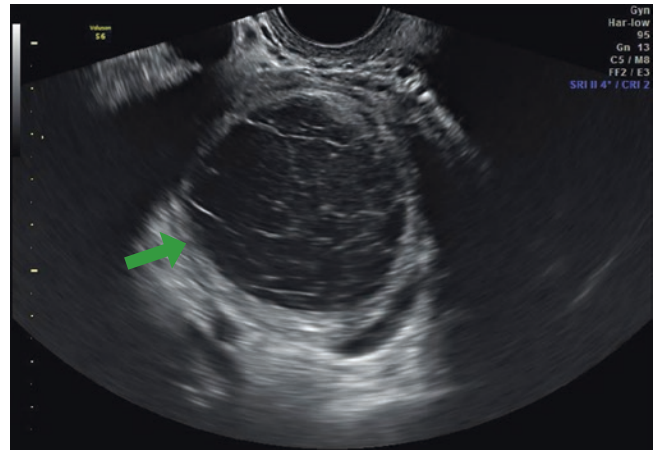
Hemorrhagic cyst of the left ovary. Transverse endovaginal sonogram reveals fibrinous strands (*arrow*) and low-level internal echoes
